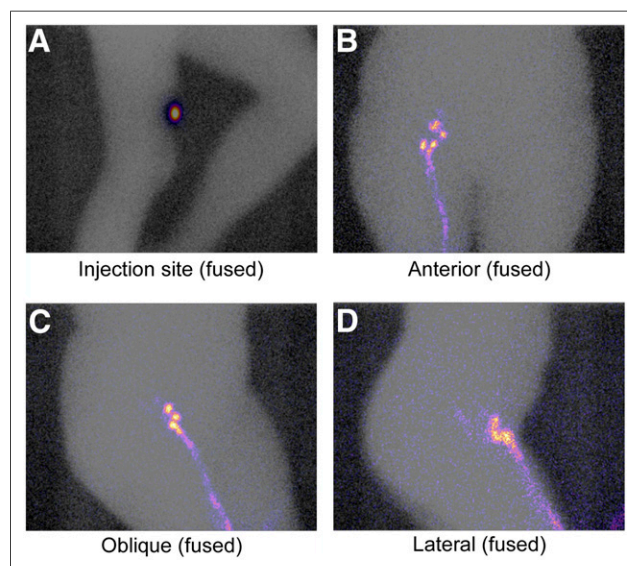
Example fused ^{99m}Tc (color) and ^{153}Gd (inverse gray scale) images from melanoma lymphoscintigraphy scan of injection site and of multiple views of inguinal lymph nodes.
